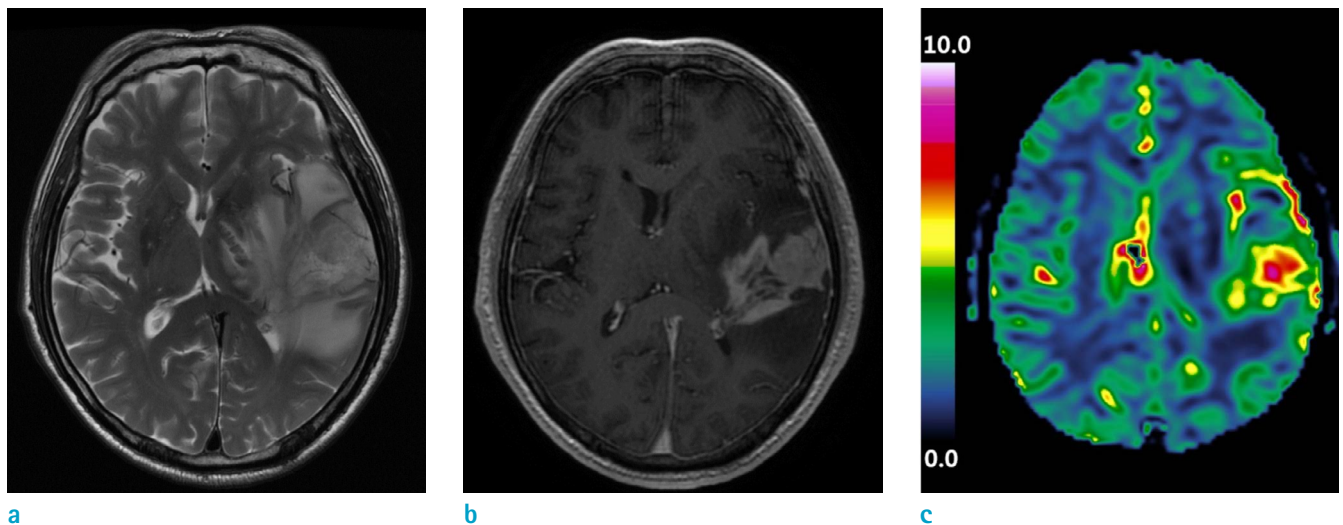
A 73-year-old male with glioblastoma in the left temporal lobe. (a) T2-weighted image, (b) T1-weighted contrast-enhanced image, and (c) rCBV map are shown. The mean rCBV value measured from the enhanced part of the tumor was 2.70. Molecular analysis revealed that both MGMT promoter and 1p19q were intact. The overall survival was 13 months.
